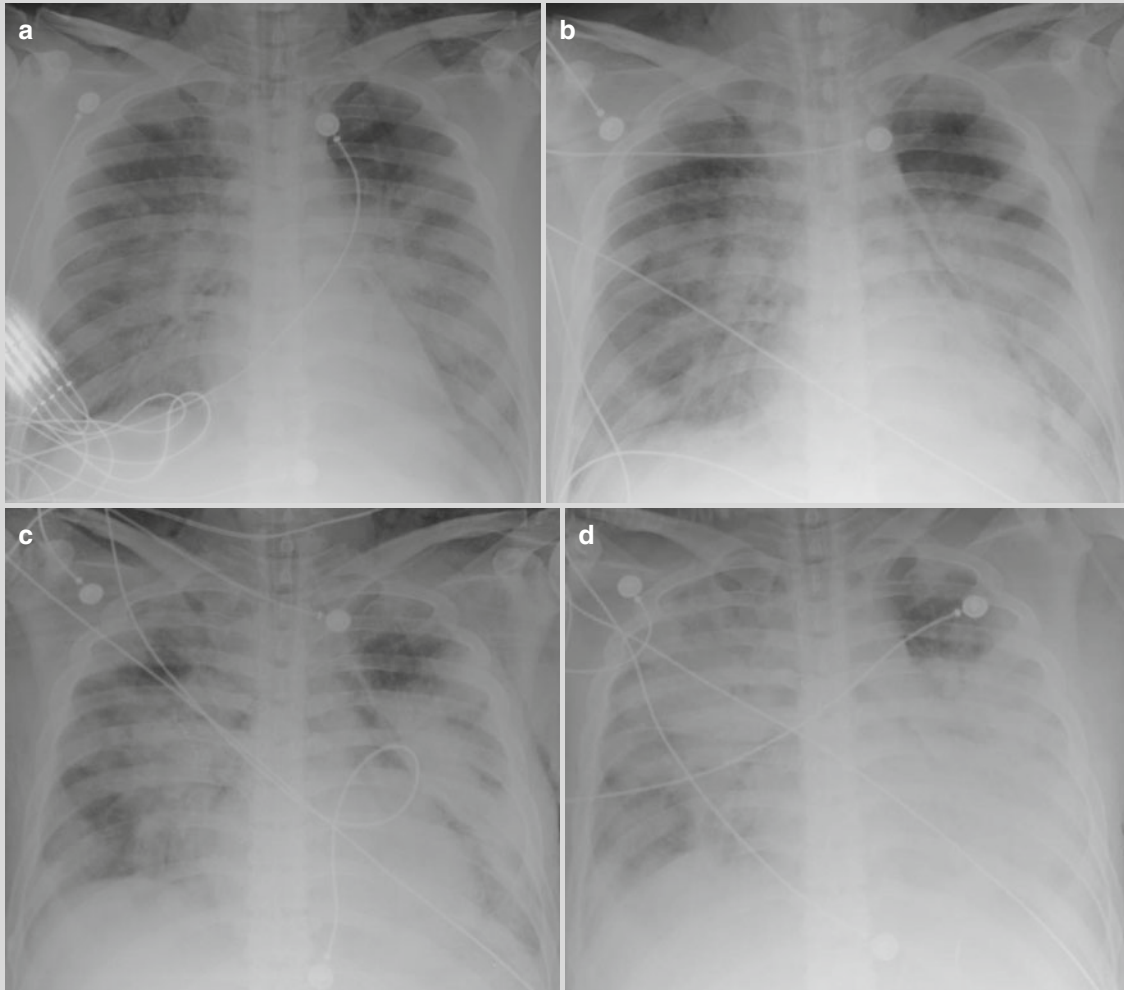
Chest X-ray showed multiple poorly defined flakes of opacity in the bilateral middle and lower lungs fields; enlarged and poorly defined hilum in both lungs; poorly defined bilateral costophrenic angles (a). Reexamination after treatment for 1 day revealed progression of the lesions. Chest X-ray showed enlarged range with multiple poorly defined flakes of opacity in the bilateral middle and lower lungs, which showed increased density (b). Reexamination after treatments for 4 days, chest X-ray showed enlarged range with consolidations in both lungs (c). Reexamination after treatments for 5 days, the lesions were shown with progression (d). Reexamination
